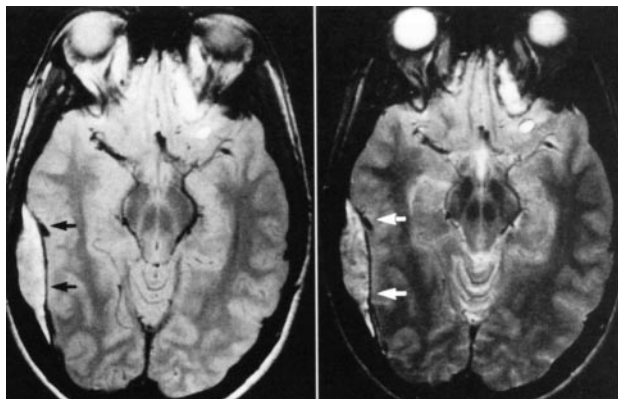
MRI epidural hematoma - left proton density-hypersignal area in temporal region right T2W- dura is seen as a hyposignal line
